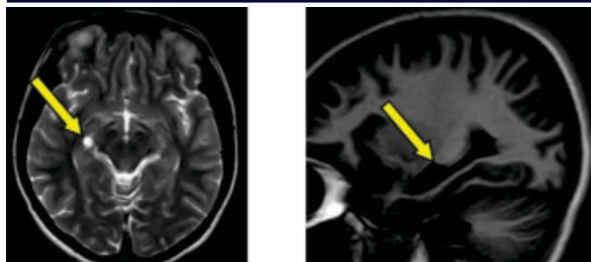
16 year old patient with 3 months history of GTCS. MRI shows hypointense on T1 and hyperintense on T2 lesion in the right medial temporal lobe - Neuroglial cyst
